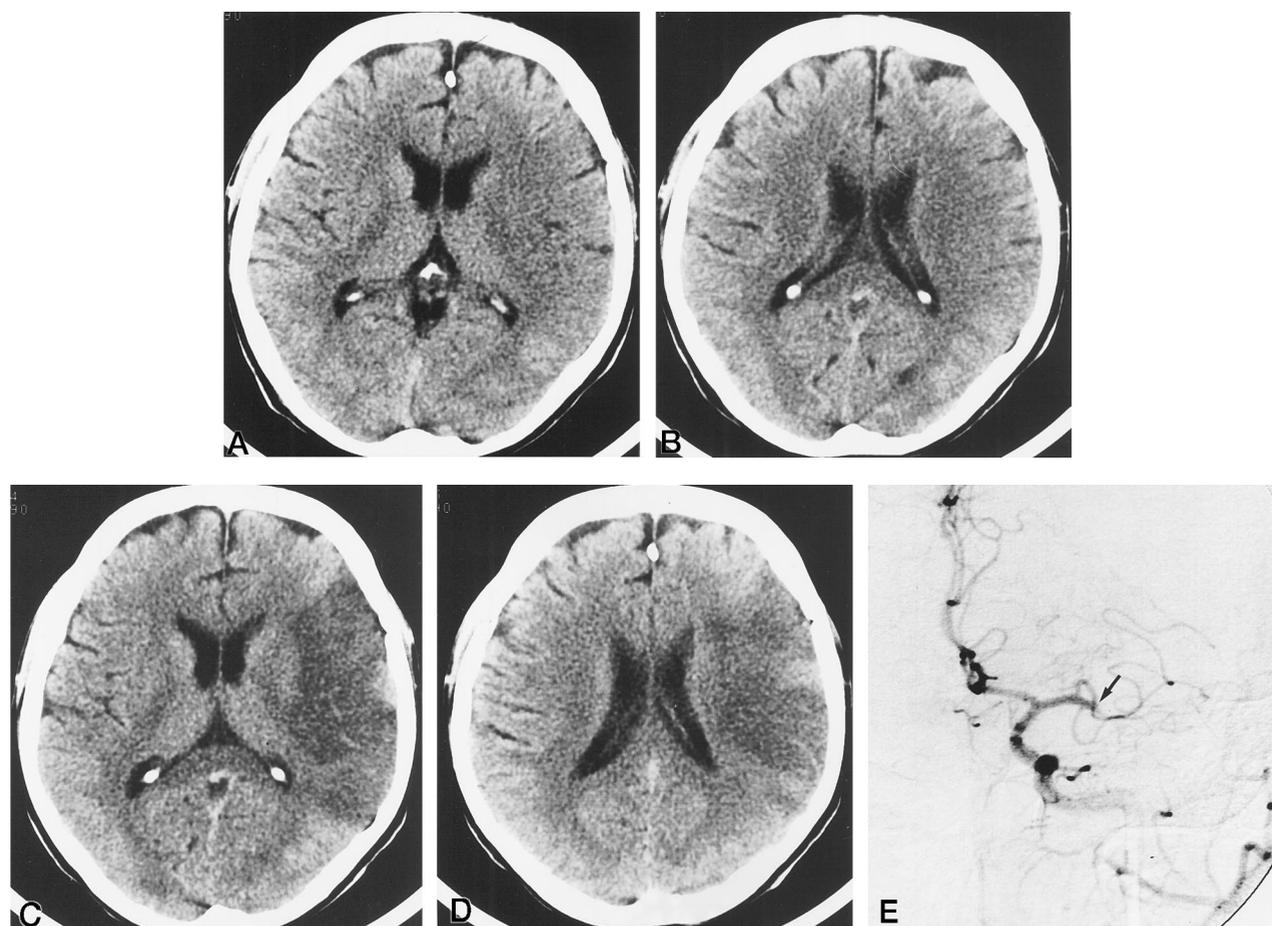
A and B, CT study in a patient 135 minutes after the onset of hemiparesis and aphasia shows hypodensity of the left insular, frontal, and temporal hemispheric cortex judged as a MESI. Effacement of cerebral sulci indicates early hemispheric swelling. C and D, CT study 1 day later shows nearly total infarction of the hemispheric cortex of the MCA territory. E, Angiography of the right carotid artery proved occlusion of the MCA (arrow) distal to the medial lenticulostriate arteries (MCA trifurcation), allowing opacification of two minor branches of the MCA. The patient survived with severe disability.
